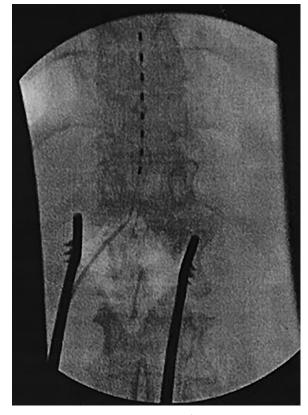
Intraoperative radiography of spinal cord stimulator lead placement.
